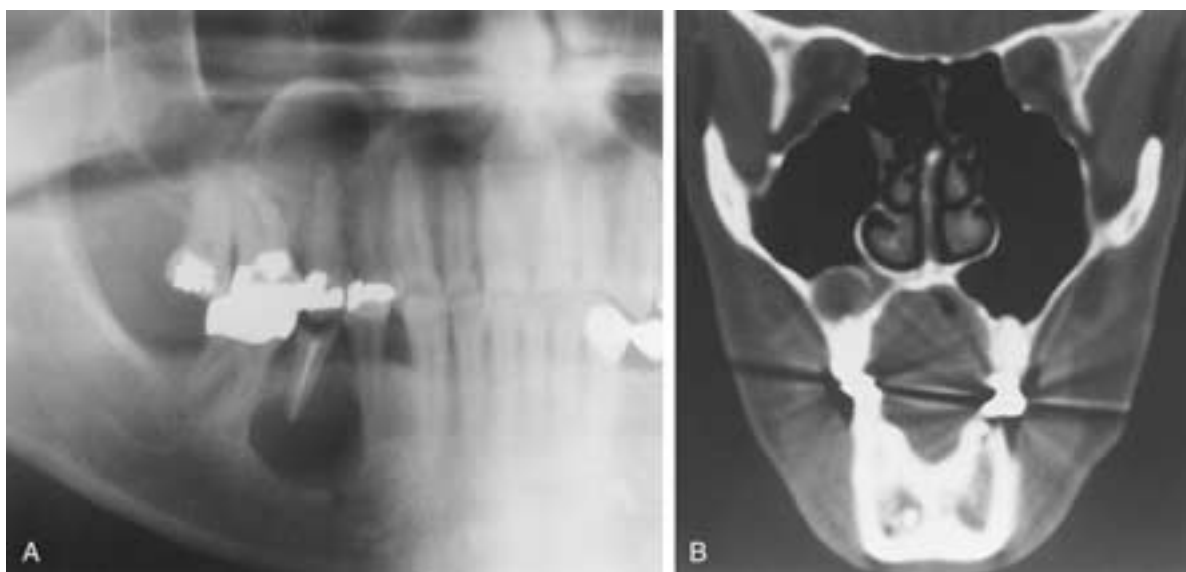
Radicular cyst. A, Pantomogram of the mandible and maxilla shows a radicular cyst around the apex of the right second premolar tooth within the mandible and around the apex of the upper right second premolar tooth. The upper radicular cyst bulges into the right antral cavity. B, Coronal CT of the paranasal sinuses shows the maxillary radicular cyst projecting into the floor of the right antrum.
